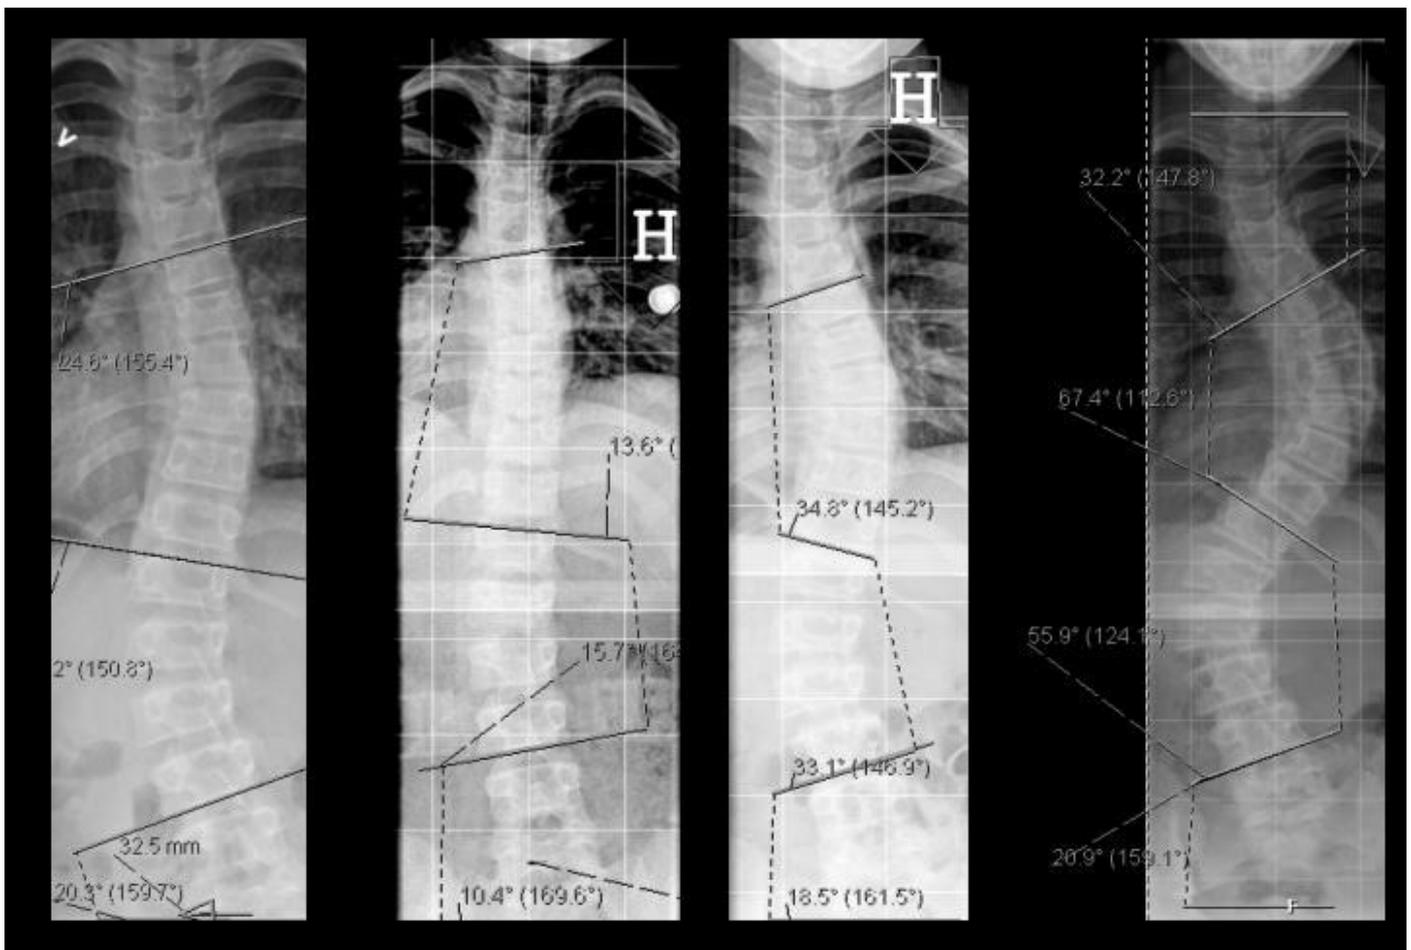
Radiographs show juvenile idiopathic scoliosis in a girl. She started bracing at age 9 years, the double shaped curve was 24.6° and 29.2°, respectively. Curves were flexible and were reduced to 13.6° and 15.7° in a rigid brace. She started to become non-compliant at age 11 years, curves increased to 34.8° and 33.1°. She stopped to use the brace at 12 years of age and did not attend any appointment for 2 years and her scoliosis had increased to 67.4° and 55.9° at 14 years of age, respectively, and she was referred for surgery.
